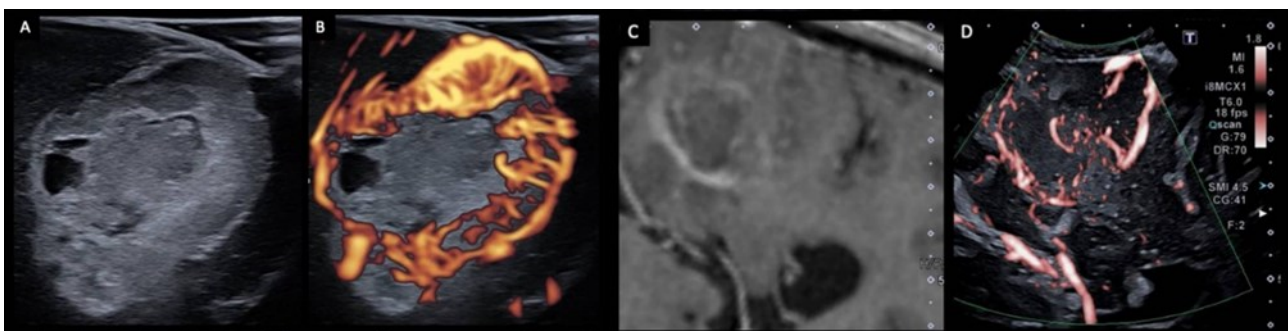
Examples of images obtained intraoperatively with assistance of intraoperative US at B-mode (A), doppler (B, D) and intraoperatively with assistance MRI © Source: [20].
